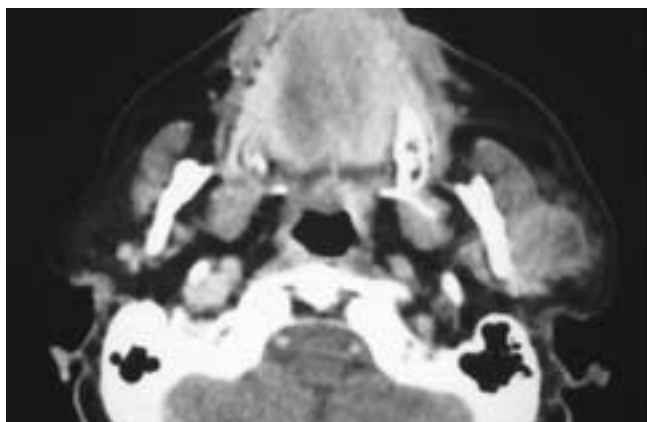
Axial contrast-enhanced CT scan shows a partially necrotic mass with irregular walls in the left parotid gland. The mass has an infiltrative margin with the adjacent parotid tissue. This patient had a high-grade MEC.
